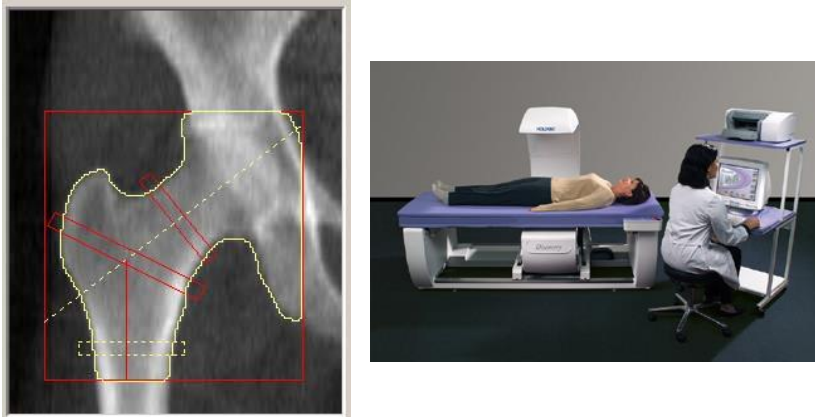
Image of the hip, as assessed with dual-energy X-ray absorptiometry (Hologic Discovery W, Tromp Medical B.V.).
